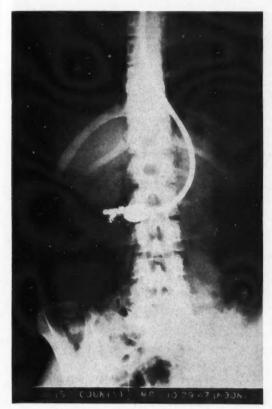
Roentgenogram taken at San Francisco Hospital at the height of the patient's pseudodistention, revealing no significant gas in the bowel.
